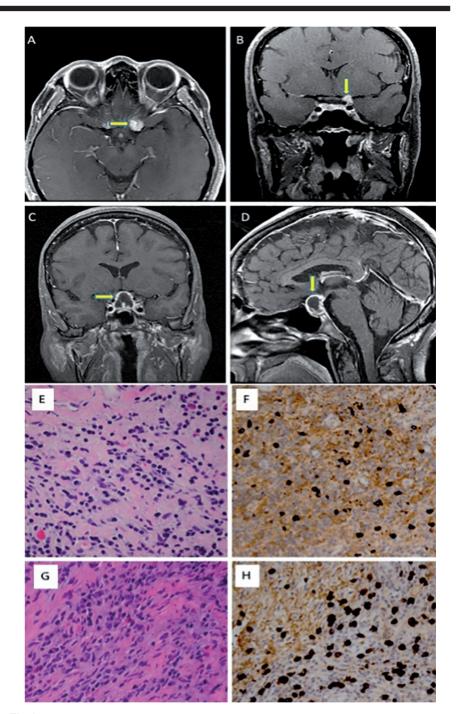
Case 1: Axial and coronal MRI showing soft tissue mas abutting left optic nerve (A-B). Case 2: Coronal and sagittal MRI images show intra/suprasellar mass (C-D). Both cases, Case 1 (E-F) and Case 2 (G-F) contained tissue fibrosis and IgG4 rich lymphoplasmacytic infiltrates.
